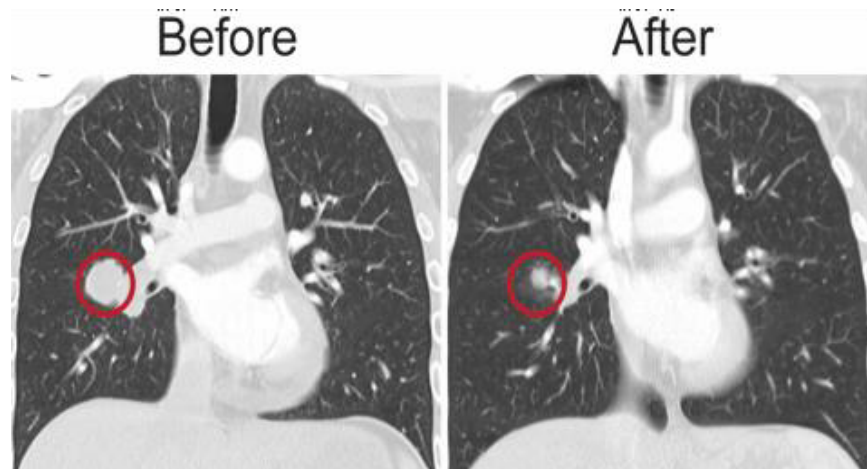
MRI scans of a patient demonstrating shrinkage of a lung metastases after 6 weeks of cetuximab and prochlorperazine treatment.
